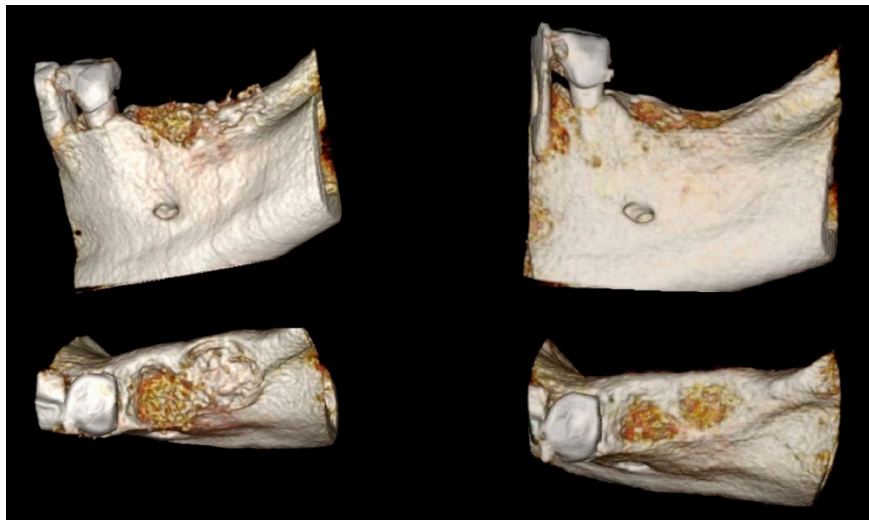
Three-dimensional rendering (OsiriX) in sagittal and axial views taken from CBCT (left) during postoperative period and (right) four months after the regenerative surgery.
